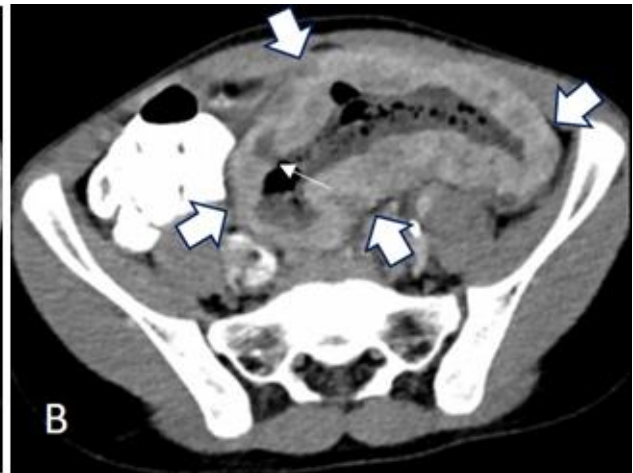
CT scan after oral, rectal and IV contrast
